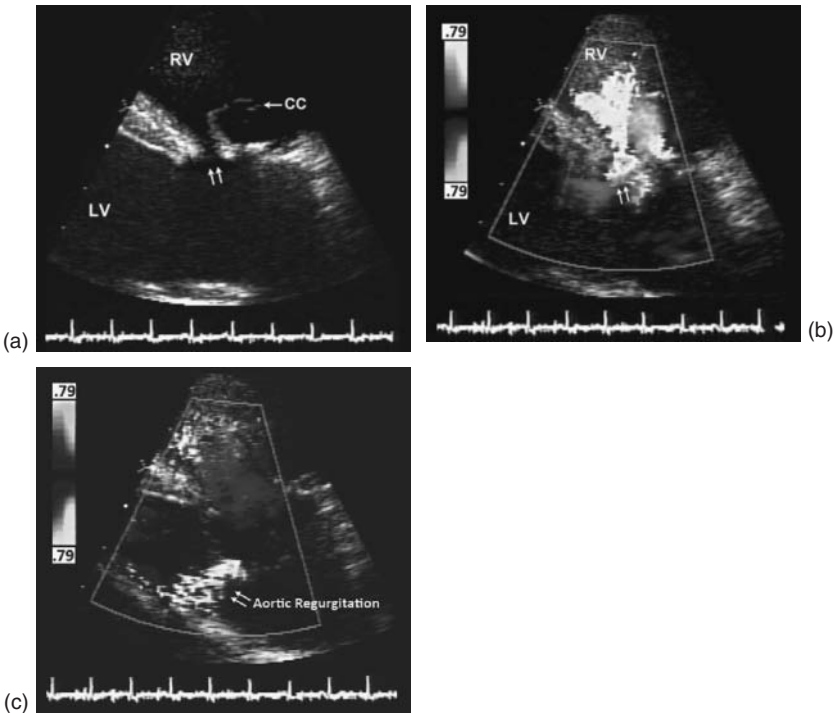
Transthoracic echocardiogram showing a supracristal defect with and without color flow Doppler in systole and diastole. The aortic valve prolapse is seen in early systole (a), as blood is ejected from the left ventricle, the anatomically unsupported coronary cusp and aortic sinus are driven into the right ventricle (RV) by a Venturi effect. Color flow Doppler shows left to right shunt across the VSD (b). In diastole (c), the intra-aortic pressure forces the aortic valve leaflet to close, but the unsupported cusp (right or noncoronary) is pushed down into the left ventricular outflow tract away from the opposed coronary cusp, resulting in AR.
